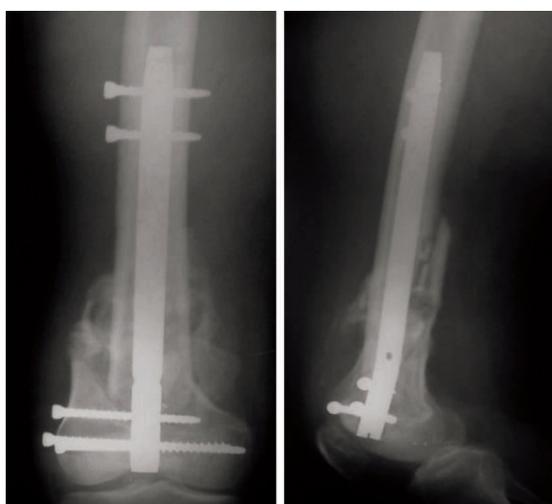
Post-operative X-rays Showing Implant insitu with good fracture healing in reasonable alignment
